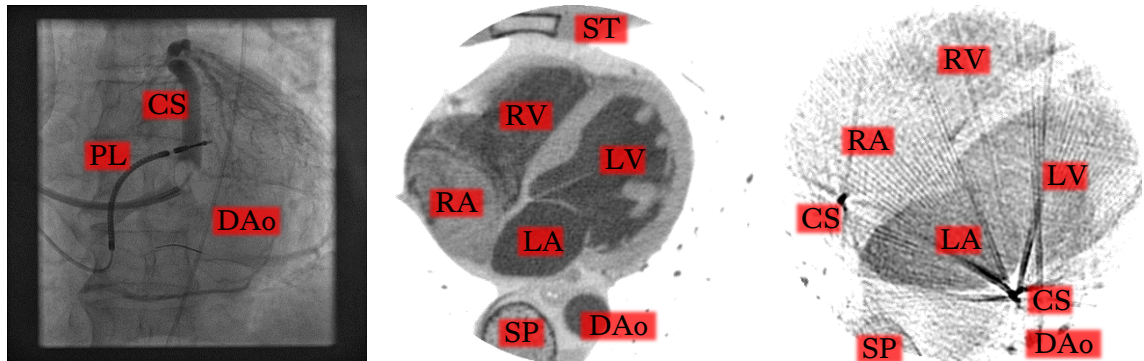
a) A contrast enhanced coronary angiogram taken with a flat panel X-ray fluoroscope in PA view. Catheters are inserted into the DAo and CS and a pacing lead (PL) is inserted into the RV. b) Four-chamber axial cross sectional tomographic slice of a heart from a CT scan and c) from a 3DRx tomographic reconstruction. A catheter inserted into the CS of the patient during the 3DRx scan produces large streaking artefacts. The cardiac chambers, DAo, spine (SP) and sternum (ST) locations are labelled.
